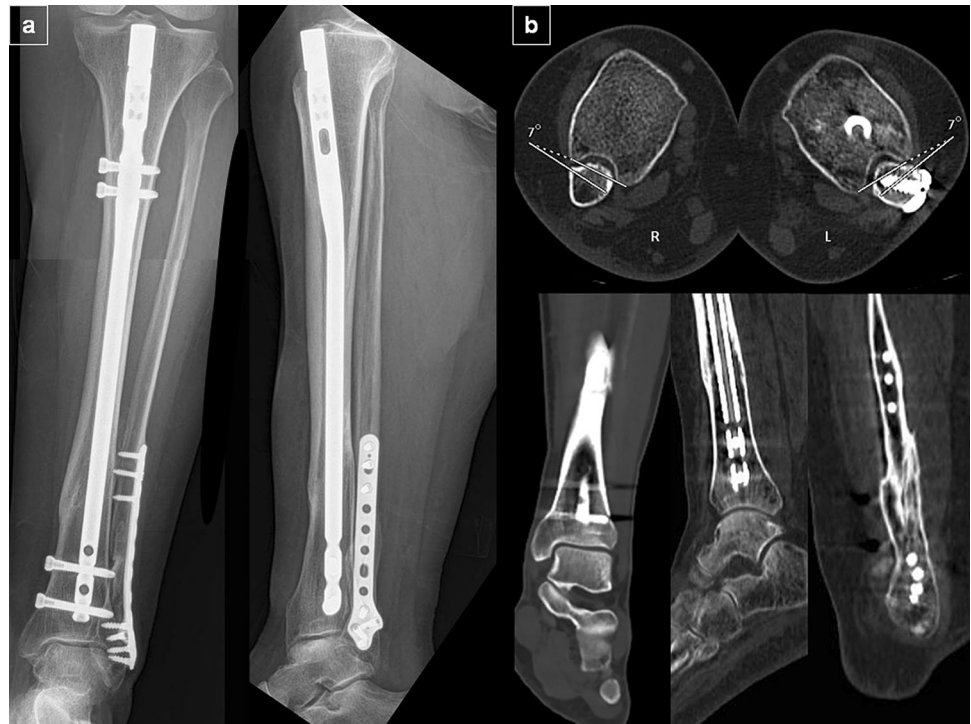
37-year-old male patient admitted after the pedestrian-vehicle accident a displaced type II open fracture of the distal third of left tibiofibular shaft b axial CT images of the distal tibiofibular joint of right and left ankles
